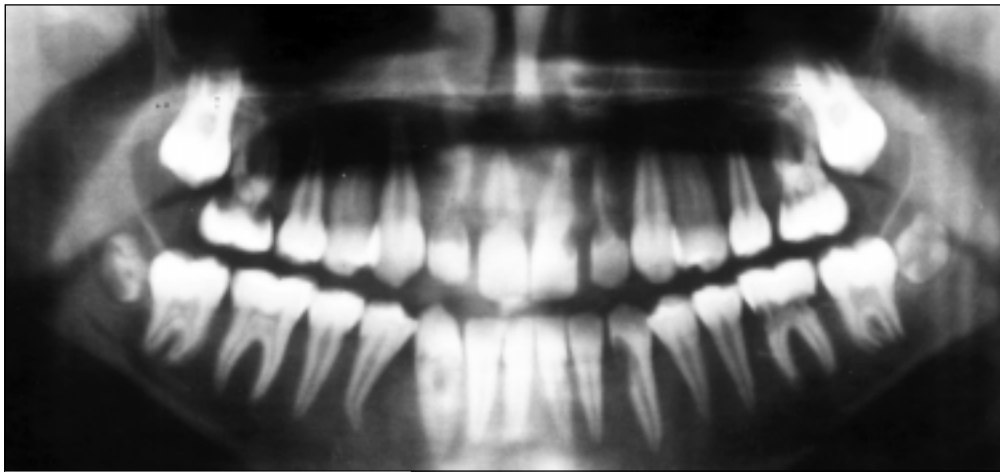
Orthopantomogram of patient B.
